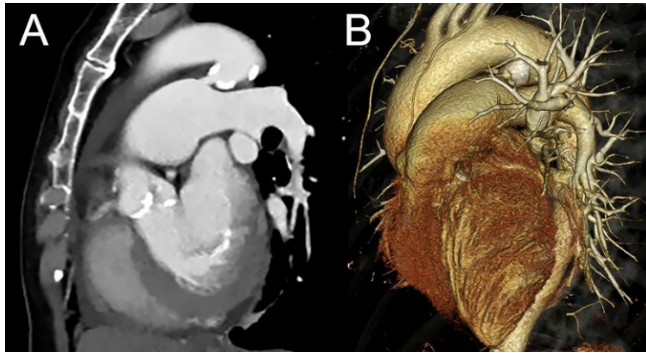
(A) Preoperative and (B) Three-dimensional computed tomography showing a 44-mm calcified ductus arteriosus saccular aneurysm.
